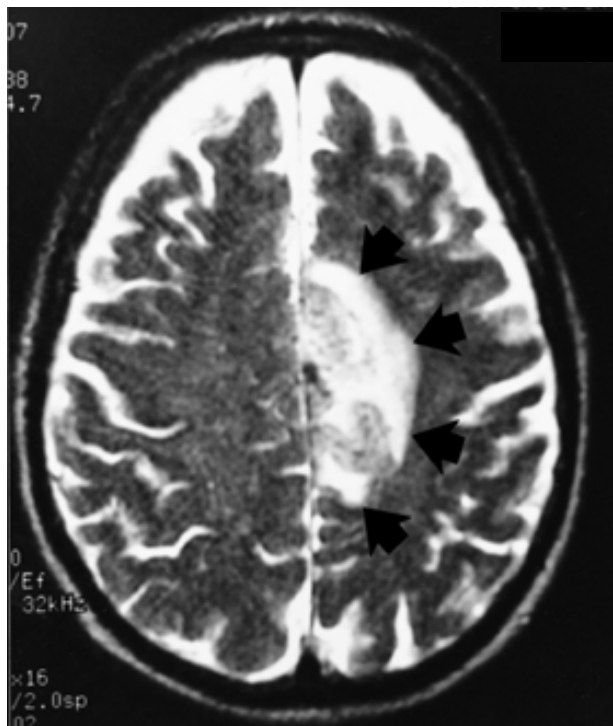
T₂ weighted magnetic resonance image of the brain showing left frontoparietal parasagittal mass with associated edema (arrows).
